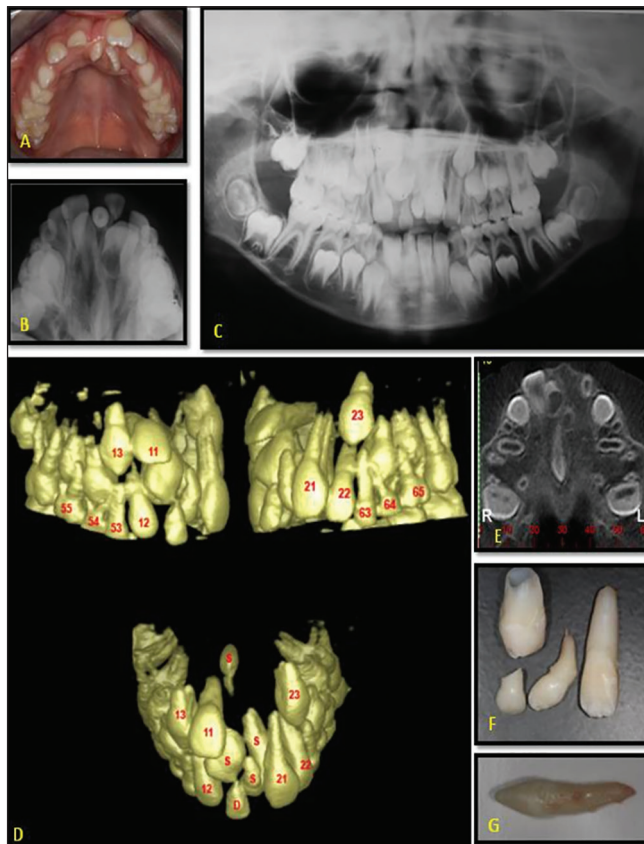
(a) Occlusal view showing abnormal supernumerary teeth in the anterior superior region and tilting of the palatal raphe; (b) Occlusal radiograph of the maxilla; (c) Panoramic radiograph demonstrating the presence of supernumerary teeth in the anterior superior region and palatal raphe; (d) The three-dimensional reconstruction showing the presence of abnormal and supernumerary teeth (in maxilla and palate); (e) Axial section; (f and g) Abnormal supernumerary teeth ($n = 4$) and deciduous tooth removed.
